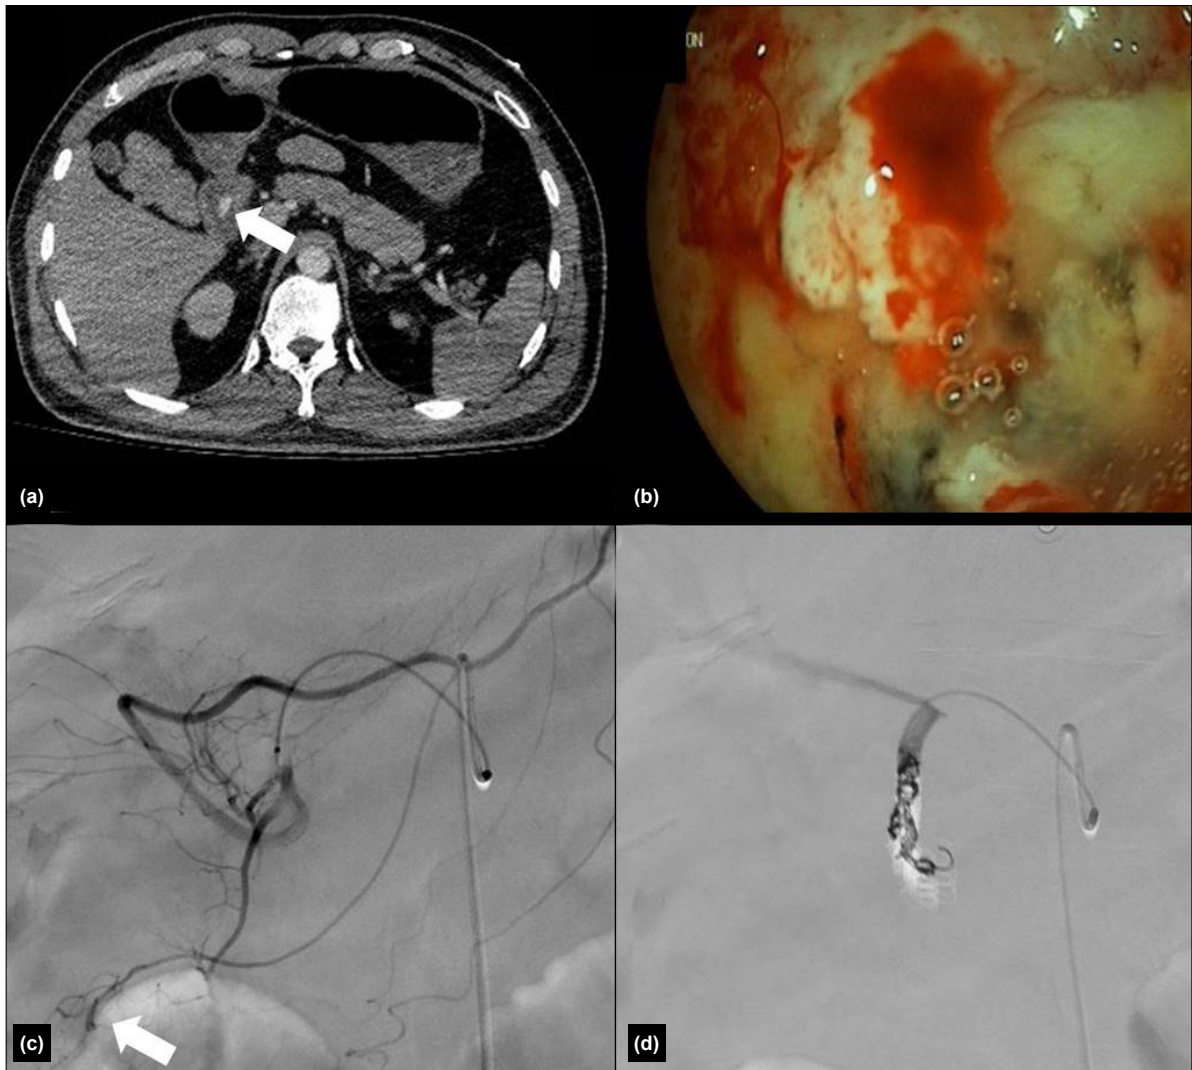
A 73-year-old man presenting with a bleeding duodenal ulcer. An axial contrast-enhanced computed tomography (CT) image (a) reveals active bleeding in the duodenum (arrow). Although the bleeding ulcer was identified on endoscopy, attempts to control the hemorrhage were unsuccessful (b). Celiac angiography (c) demonstrated active bleeding from the gastroduodenal artery (arrow). The bleeding was successfully managed by embolization of the gastroduodenal artery using microcoils (d).
